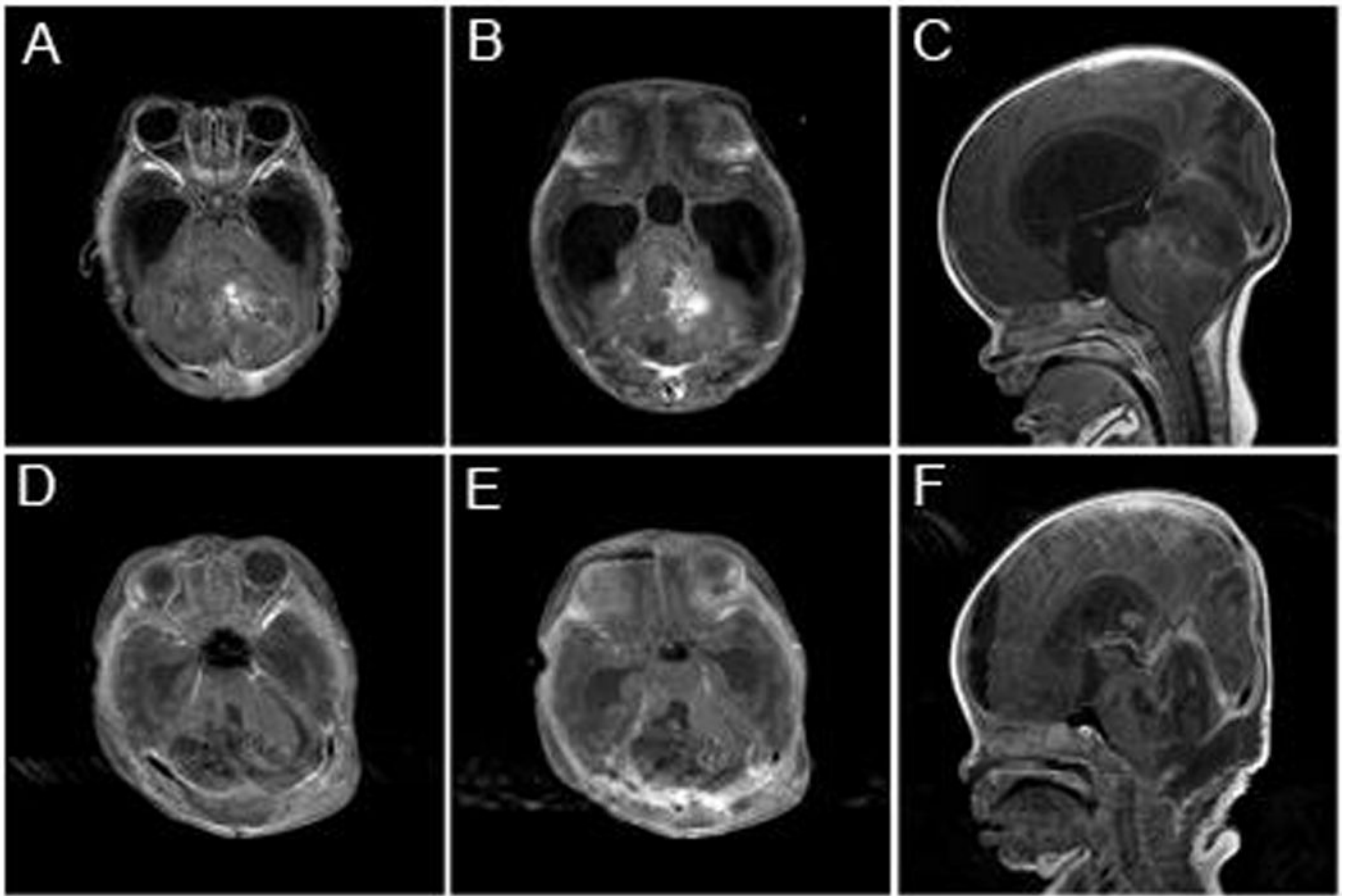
Patient 16 was a 1 month-old girl that presented with increased head size and fussiness. Axial (A and B) and sagittal (C) post-gadolinium T1 MR images demonstrated a large enhancing posterior fossa mass with significant hydrocephalus. The patient underwent a suboccipital craniotomy and resection. Post-operative axial (D and E) and sagittal (F) post-gadolinium T1 images demonstrated resection of the mass. On pathology the patient was found to have a medulloblastoma with myoblastic differentiation.
